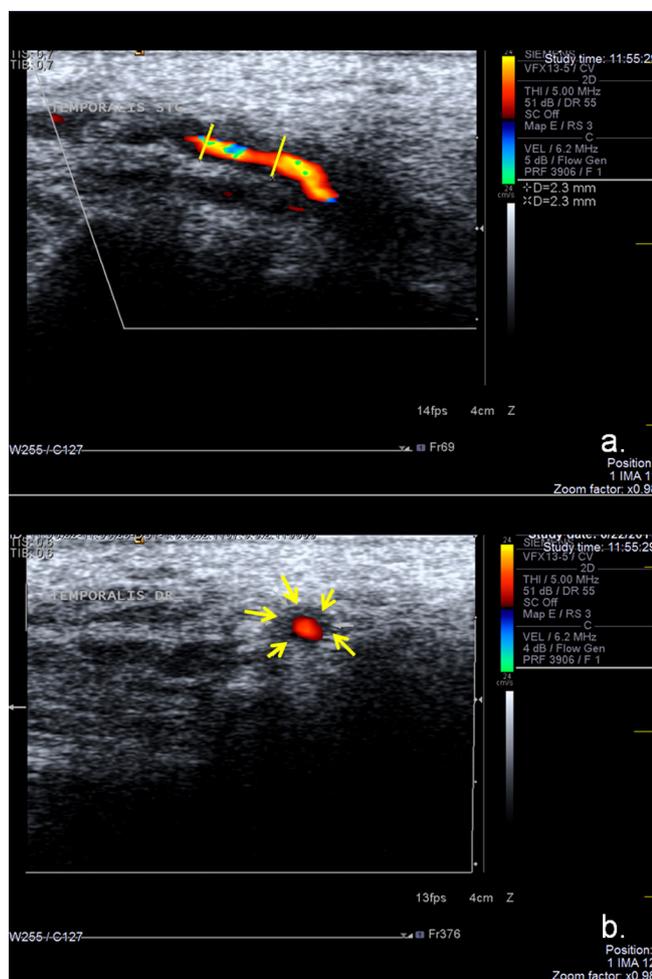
Case 2. Temporal arteritis in a 65-year-old woman. Colour duplex ultrasound examination of the temporal artery, longitudinal (a) and axial (b) sections, showing pronounced concentric hypoechoic mural thickening – 'halo sign' (lines and arrows).
